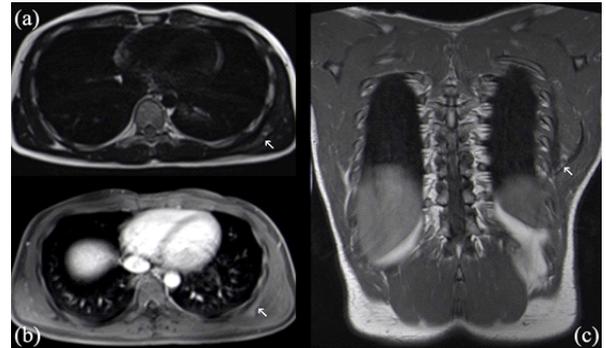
Elastofibroma Dorsi (arrow) of left infrascapular region on MRI: T1 weighted pre contrast axial (a) & coronal (c) sections and post contrast fat suppressed axial (b) sections show effacement of the fat plane between the serratus anterior and latissimus dorsi muscle with elliptical soft tissue thickening.
